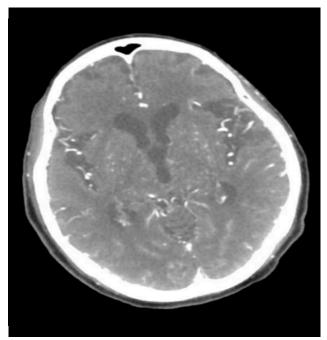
CT angiography of the head showing short segment nonopacification of right M2 (insular segment) branch with distal reconstitution was seen possibly representing a high-grade stenosis vs occlusion with collateral flow.
